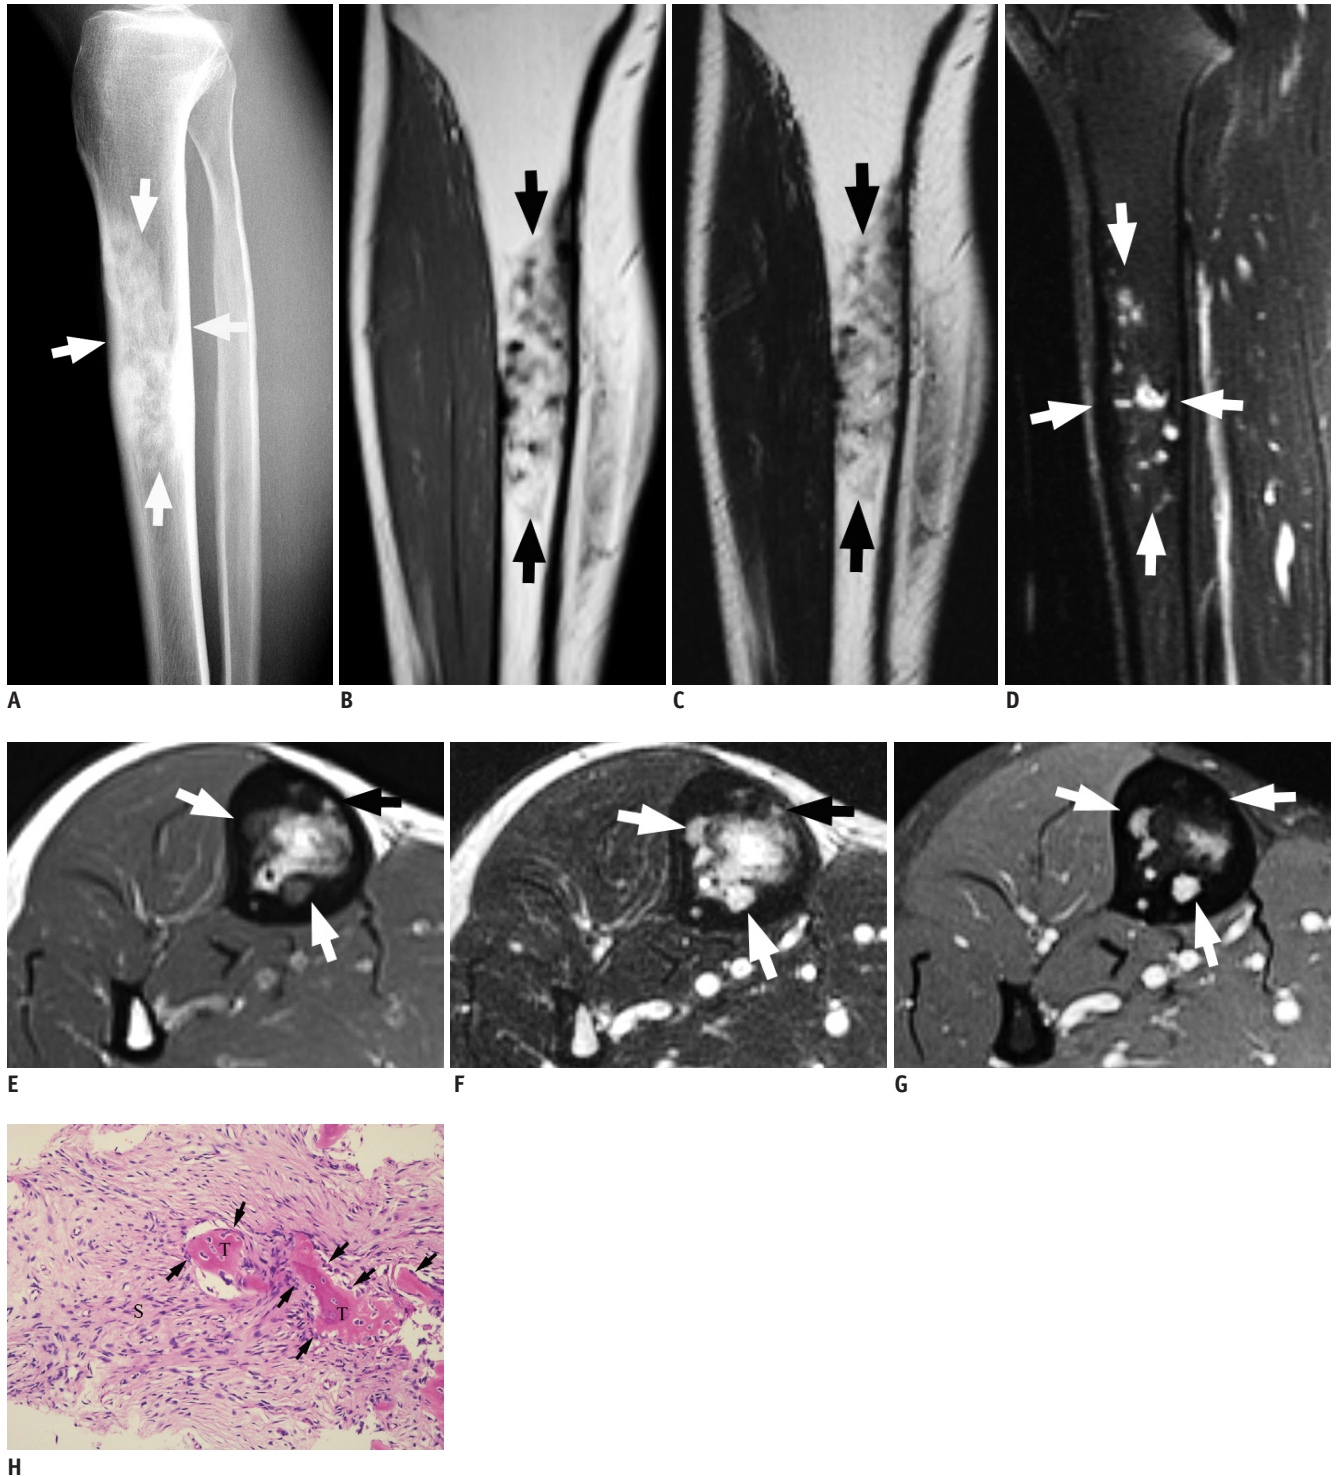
41-year-old woman presented with incidental radiographic abnormality in right tibia during evaluation of tingling sensation in right foot.
